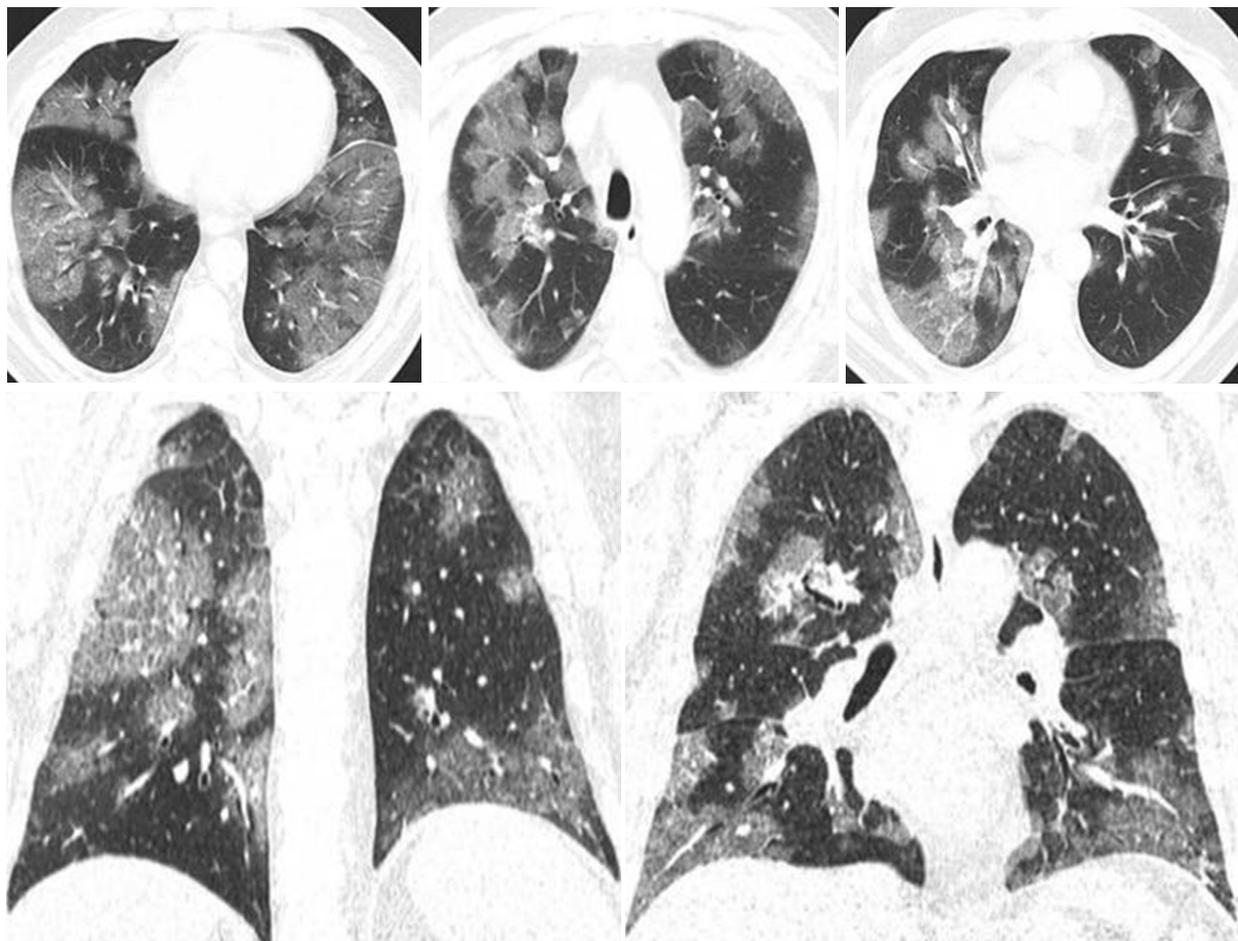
Male patient, 60 years old, was complaining of chest pain, dry cough and dyspnea and was confirmed to be COVID-19 by RT-PCR. These axial and coronal (lung window) non-contrast CT chest images show diffuse multifocal ground glass opacities involving both lungs. Both upper and lower lobes have score 5 (with $\geq 75\%$ involvement), while middle lobe has score 4 with ($50\% < 75\%$ involvement), so total CT lung severity score is 24 with 96% of lung involvement
